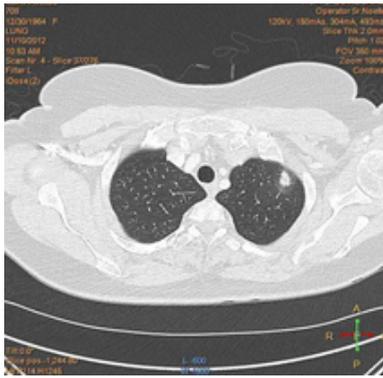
(a): Lung metastases on CT scan before treatment.
